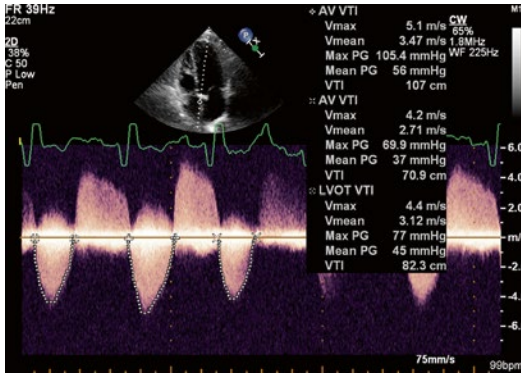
Continuous wave Doppler recording of aortic flow as sampled from the left ventricular apical window in a patient with atrial fibrillation. Peak gradients in these three beats show a range of values from 70 to 105 mmHg with mean gradients varying from 37 to 56 mmHg. Sampling only one beat in this situation could lead to significant inaccuracies in determining the severity of stenosis in this patient
